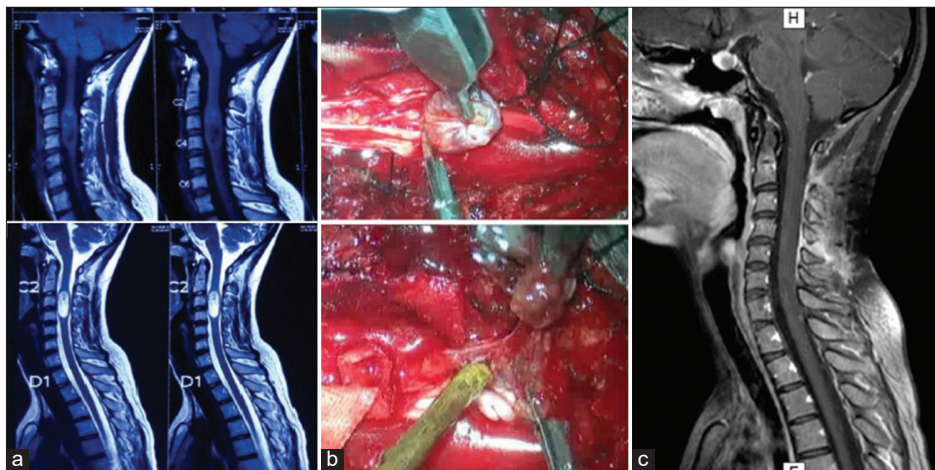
Preoperative magnetic resonance imaging (a) intraoperative (b) 3-month postoperative (c) imaging of a patient with an ependymoma.
